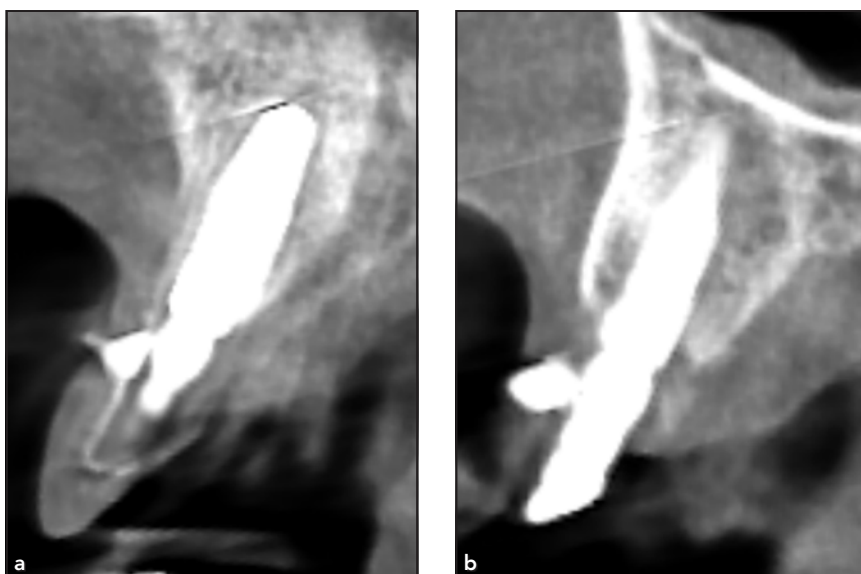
CBCT images of the augmented buccal bone plate at implant sites (a) 11 and (b) 12 after 4 years of follow-up.
